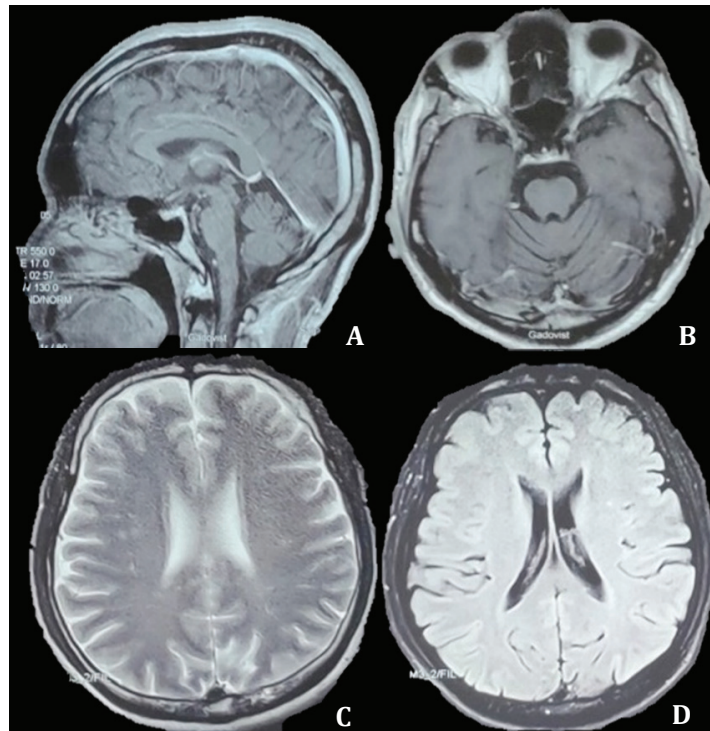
Brain MRI Sagittal and Coronal View: Widening of the Plica is Suggestive of Early Signs of Cerebellar Atrophy
